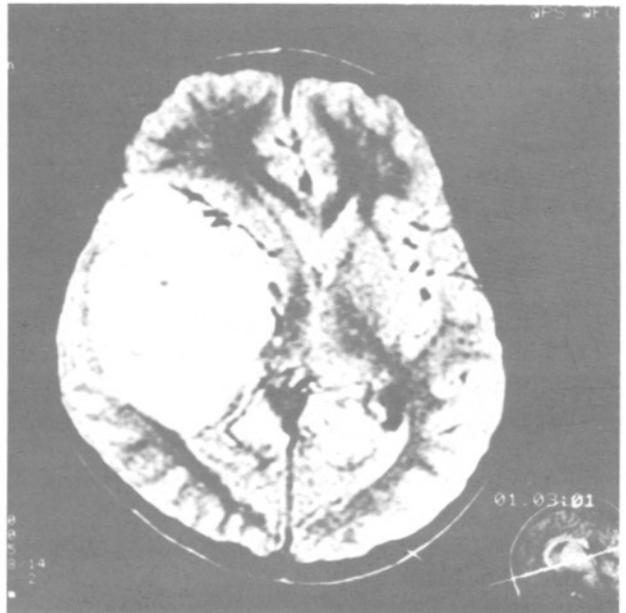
Proton density weighted axial MR image showing a right temporal mass with heterogeneous hyperintense haemorrhagic center. The peripheral zone of the tumour surrounding the haemorrhagic and necrotic center is homogeneously hyperintense.
